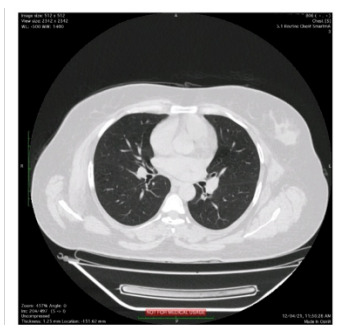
A. Transverse section of CT-Chest
